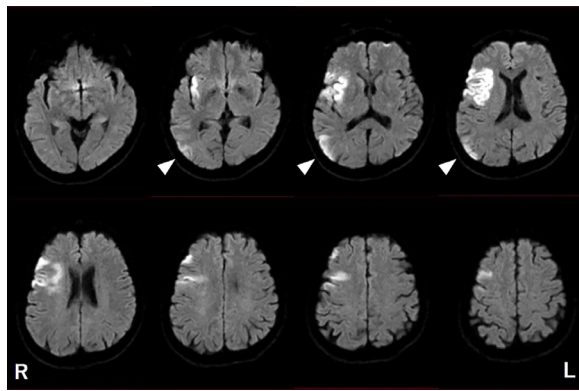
Diffusion-weighted magnetic resonance images of the patient's brain. Fresh infarction is detected in the right frontal lobe and temporo-occipital lobe. The latter (arrowheads) is considered associated with the patient's complaint.
